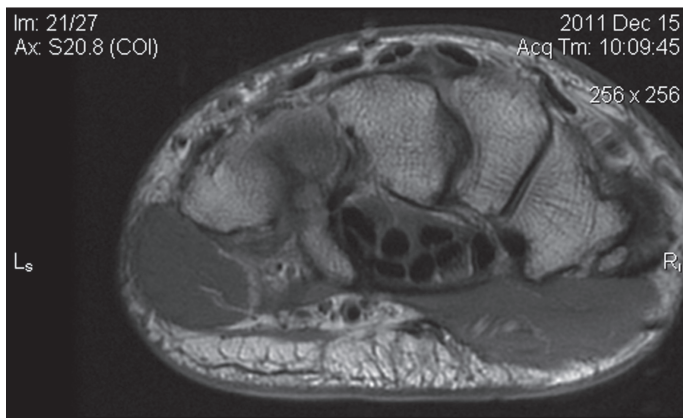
An axial slice proton density weighted MRI image through the patient's wrist reveals the nondisplaced fracture through the base of the hook of the hamate as suggested by the decreased signal intensity (darker region). Also note the proximity of the flexor tendons to the hook of the hamate.
